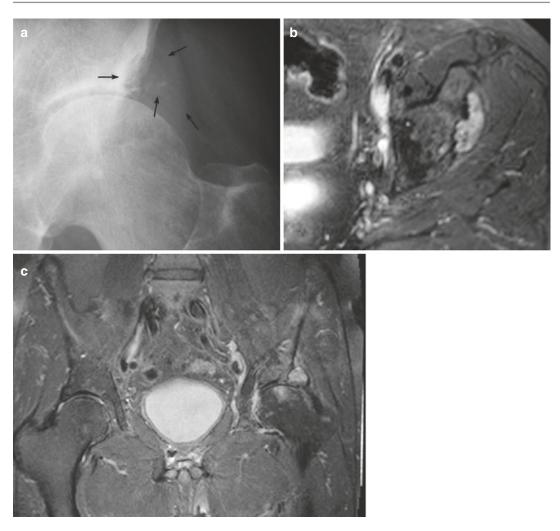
(a–c) Paralabral cyst of the left hip. (a) Standard radiograph; (b) axial fat-suppressed T2-weighted MR image; (c) coronal fat-suppressed TSE T2-weighted MR image. Plain radiography (a) reveals the presence of a sclerotic defined erosion at the superolateral aspect of the left acetabulum (*arrows*). On axial and coronal FS TSE T2-weighted MR images, there is a multicystic structure within the acetabular labrum, extending at the lateral
